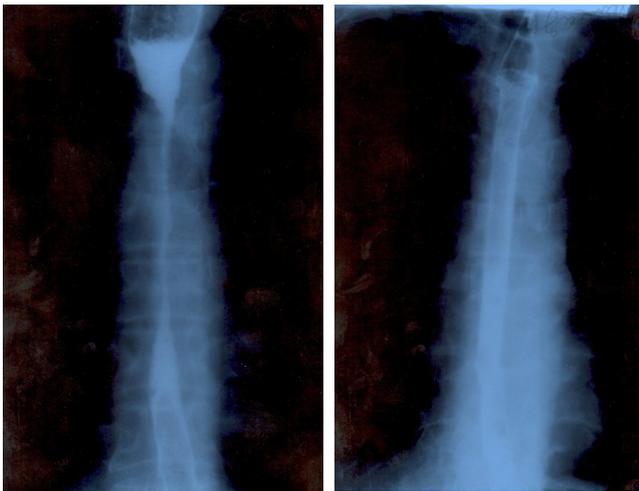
X-ray pattern before and after stenting
